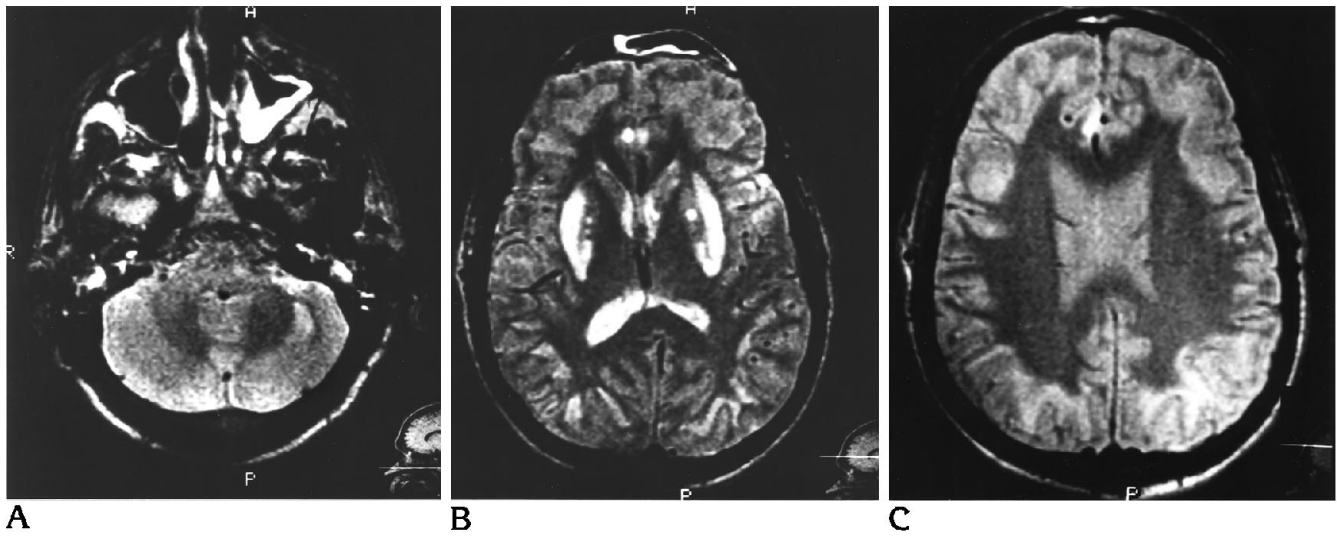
Hyperintense lesions on T2-weighted (A and B) and proton density-weighted (C) MR images 4 days after ingestion involve the putamina and peripheral cerebral and cerebellar white matter. The white matter lesions spare a thin rim of subcortical white matter. Smaller lesions involve the cingulate gyri and head of the left caudate nucleus.
